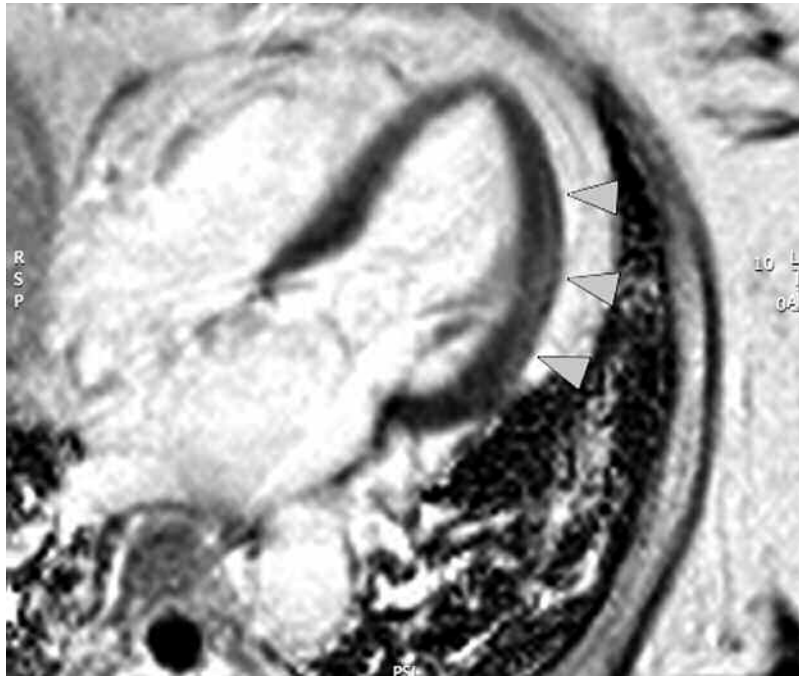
Initial cardiac MRI. Arrows indicate area of increased late enhancement in the mid-posterolateral wall region consistent with myocardial fibrosis of nonischemic origin and the diagnosis of cardiac sarcoidosis.
